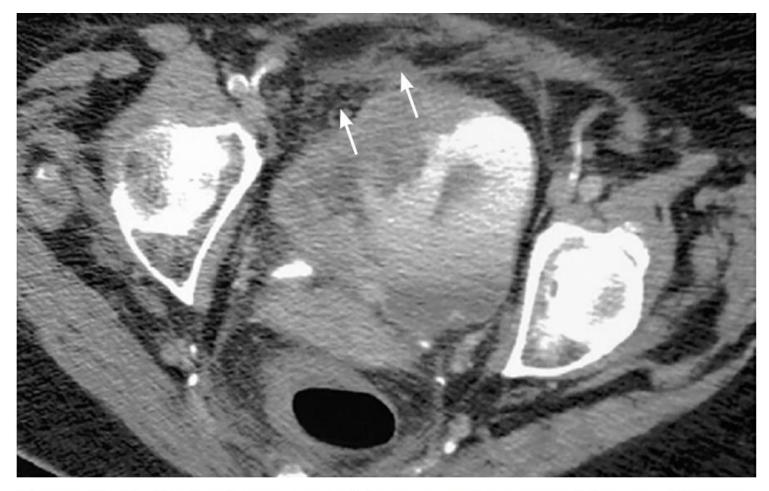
Multiphasic computed tomography urography in a 71-yearold woman with gross hematuria secondary to transitional cell carcinoma of the urinary bladder. A large polypoidal mass is visible arising from the right lateral wall with subtle perivesical fat stranding (arrows) suggestive of extramural spread.
